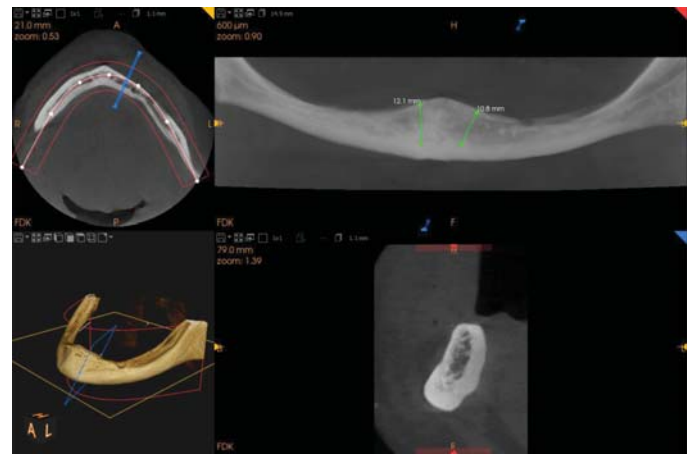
Cone-beam computed tomography (CBCT) demonstrated advanced horizontal and vertical mandibular ridge atrophy.
